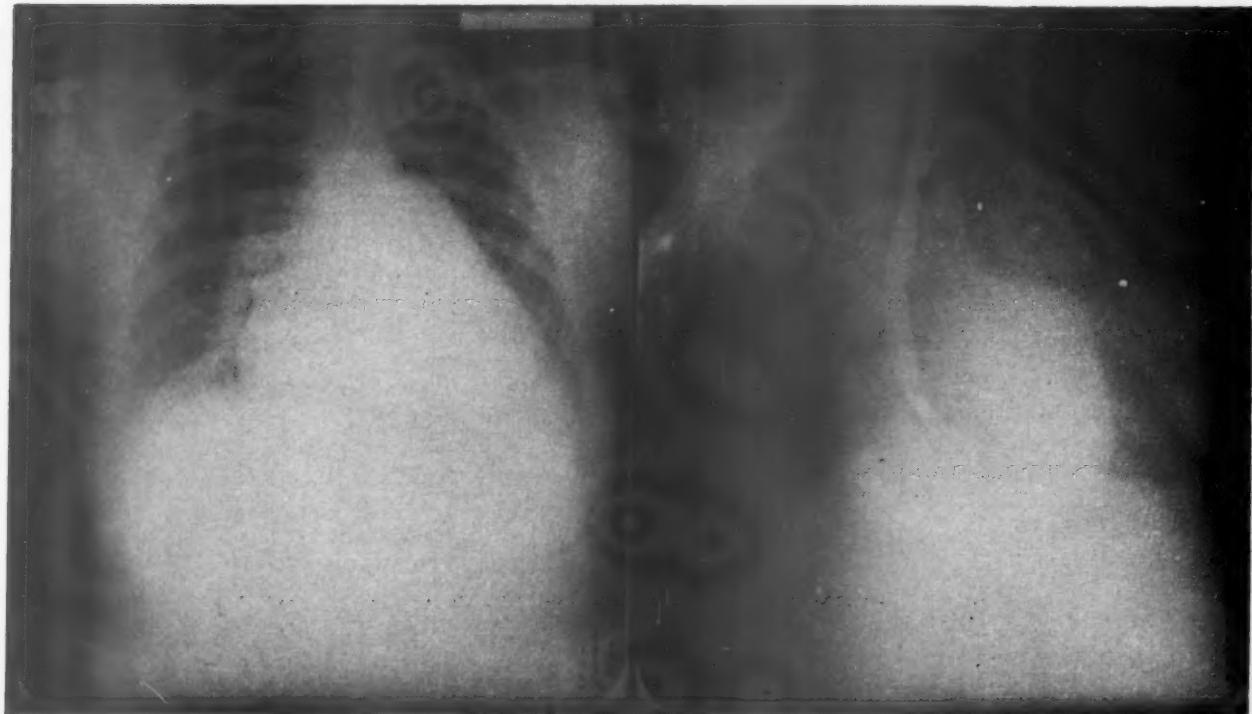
Roentgenogram of the chest (Patient P. A.) demonstrating 3-plus enlargement of the heart with considerable right ventricular hypertrophy and prominence of the pulmonary artery segment. There is 2-plus enlargement of the left atrium.
